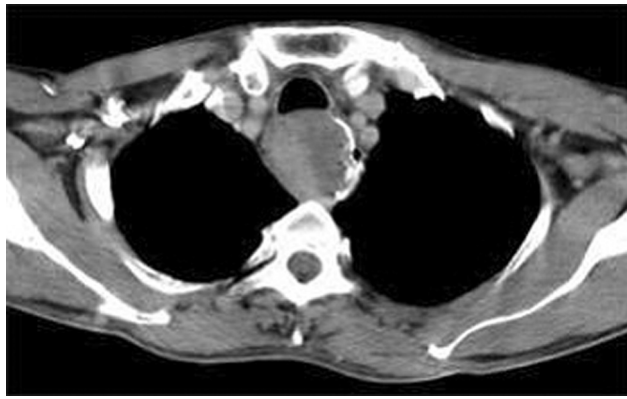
Axial contrast-enhanced computed tomography image demonstrating an irregular intraluminal polypoidal mass lesion in the esophagus suggesting a diagnosis of carcinoma esophagus.
